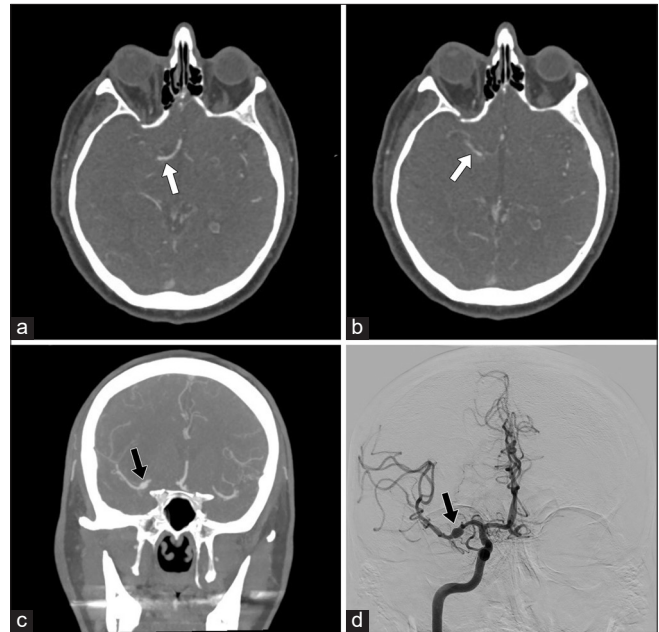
(a and b) Initial computed tomography angiography (CTA) of the head demonstrates an acute focal occlusion of the M1 segment of the right middle cerebral artery with attenuated distal reconstitution of flow (white arrows); (c) CTA of the head showing 5.2 mm fusiform dilation of the right M1 (black arrow) at the site of the mechanical thrombectomy performed 8 days prior; (d) Right internal carotid artery angiogram confirming the presence of a 5.2 mm fusiform aneurysm at the right M1 segment, compatible with a pseudoaneurysm secondary to an M1 dissection (black arrow).
